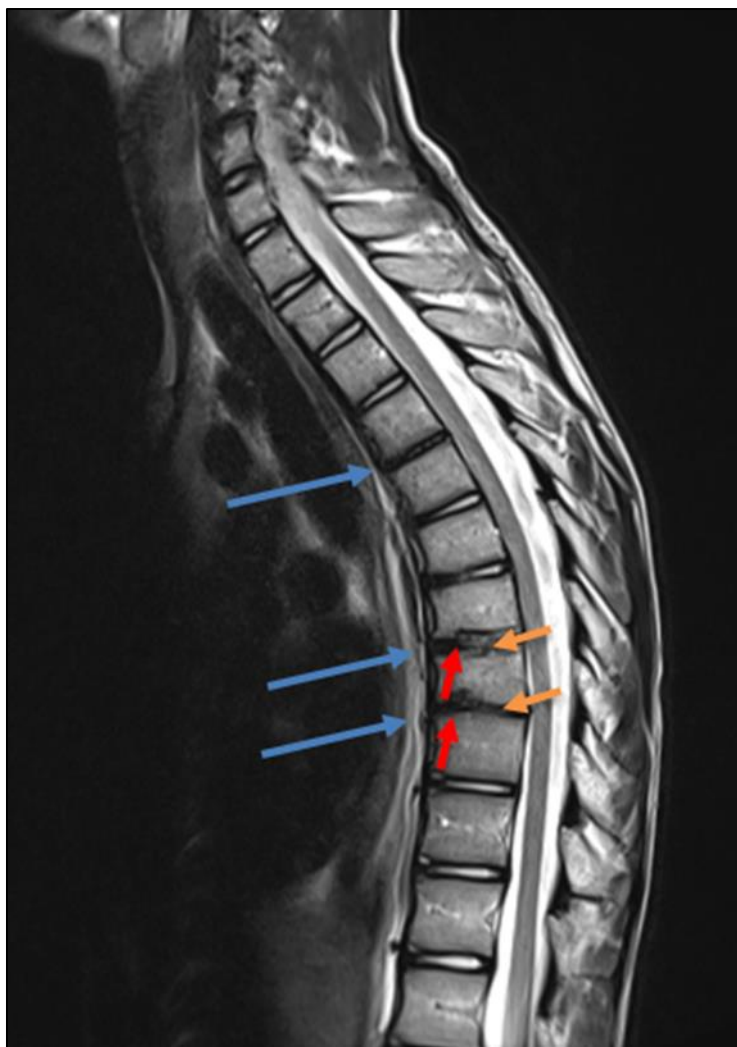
Sagittal T2-weighted image of the thoracic spine demonstrating signal loss in multiple intervertebral discs (blue arrows) with associated endplate irregularity (orange arrows) and Schmorl's nodes (red arrows).
